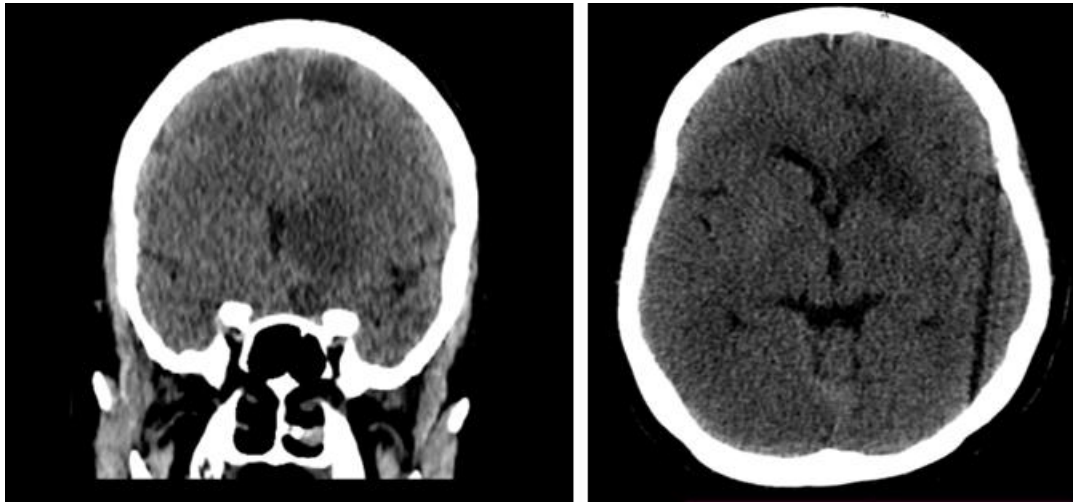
Axial and coronal section of Plain CT brain on 23/04/2026 (12 days after accident) – Multiple infarcts in supratentorial neuroparenchyma
